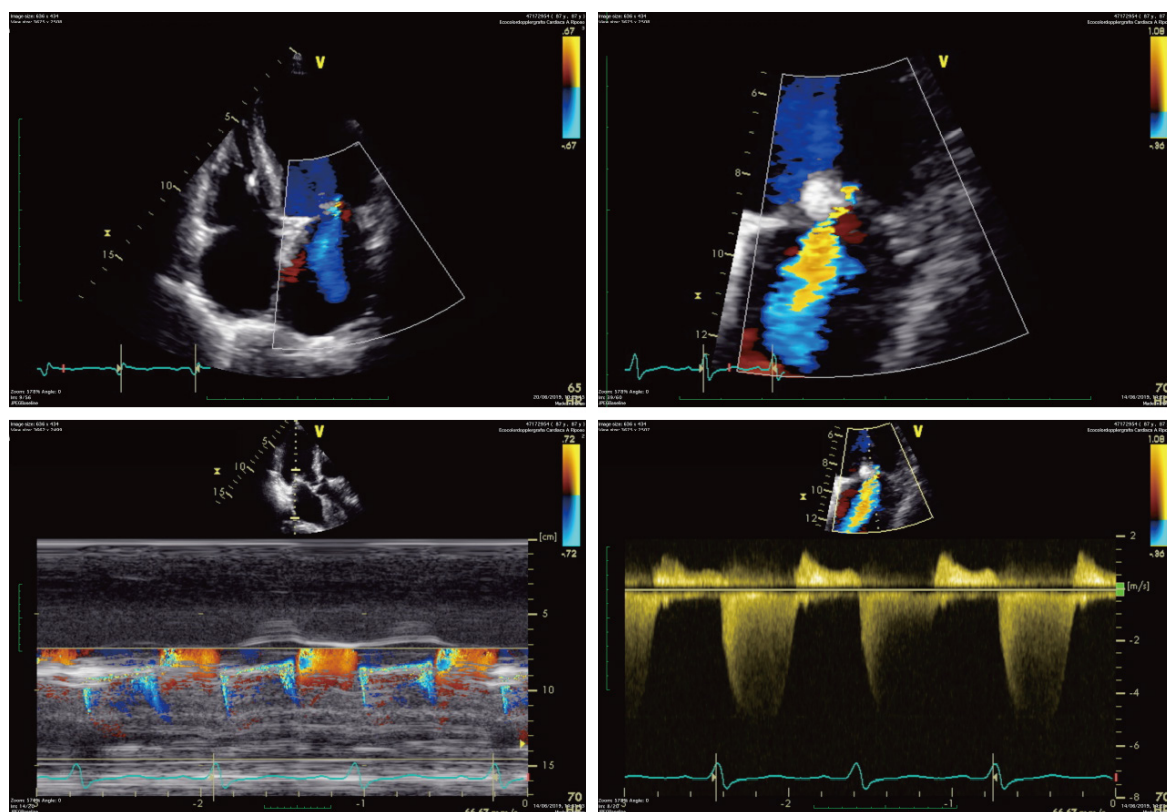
Post-procedural transthoracic Doppler echocardiography mitral valve evaluation showing mild regurgitation with acceptable mitral gradient (in particular: mean MV gradient of 3 mmHg, an effective orifice area of 14 mm² and a MV area of 3 cm²)
